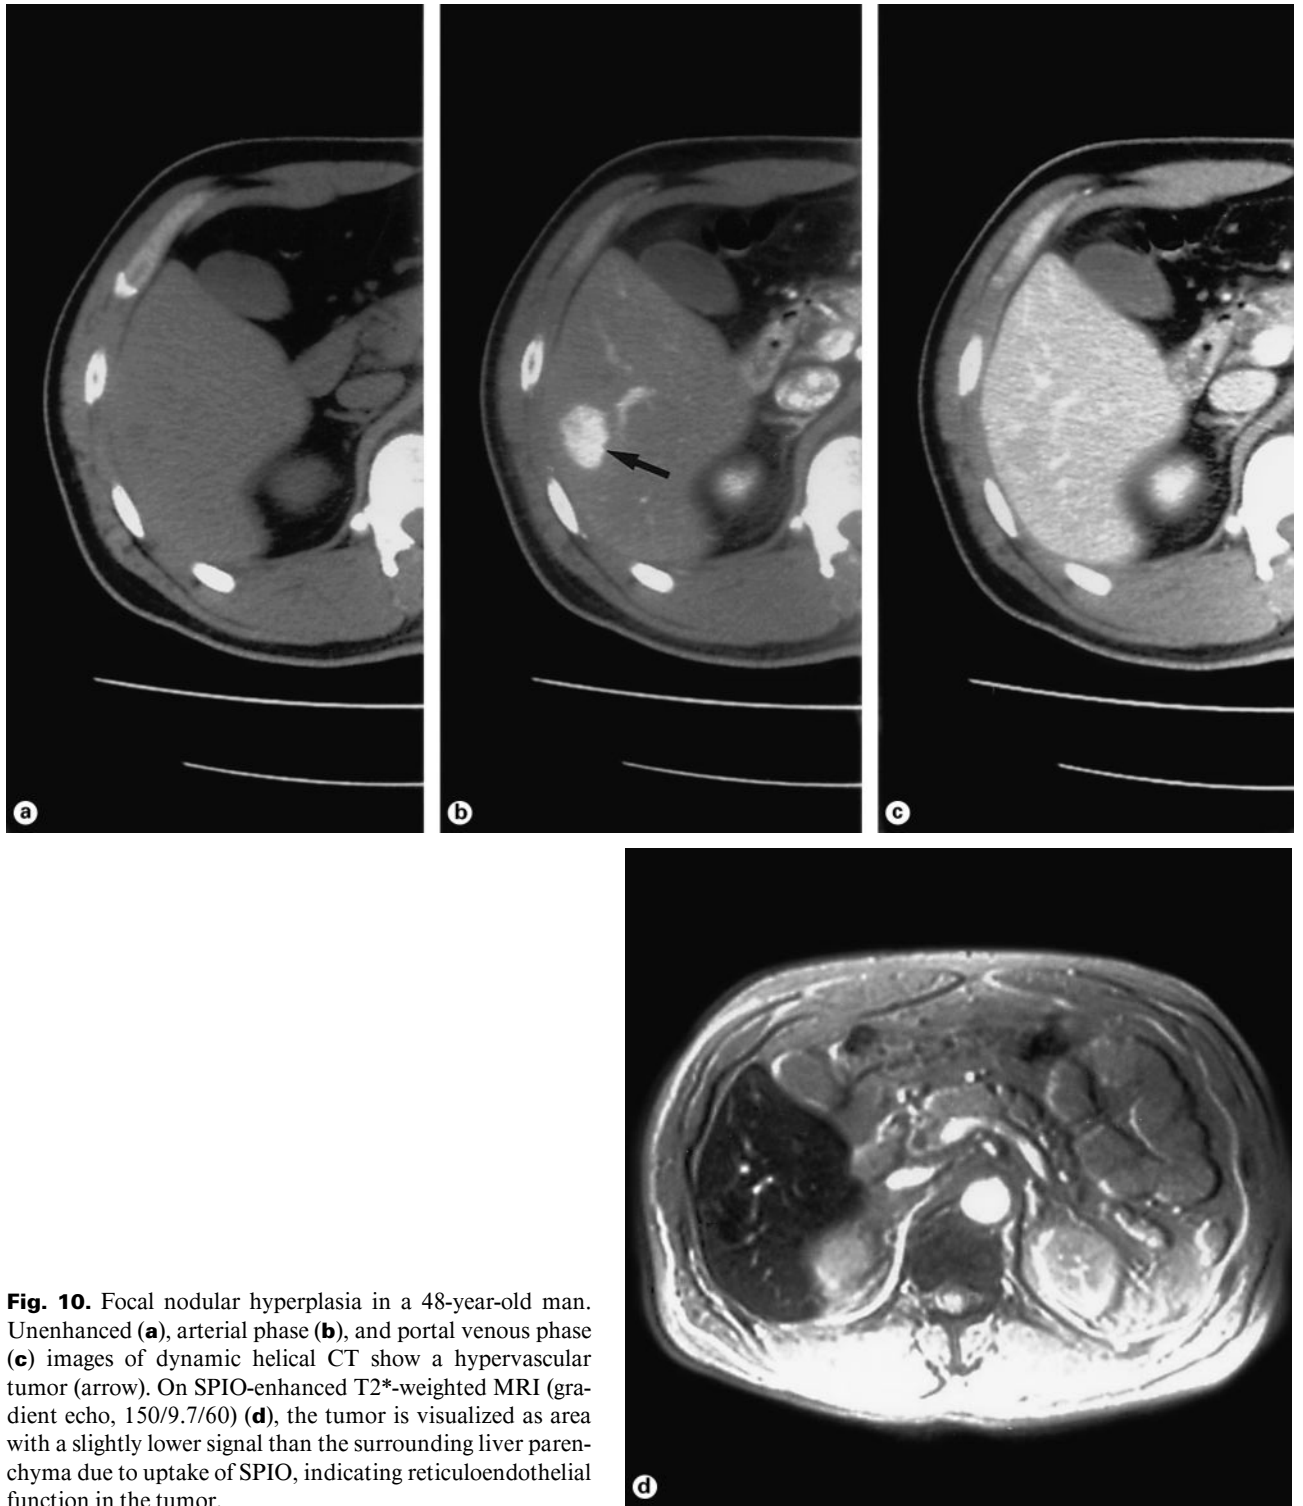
Focal nodular hyperplasia in a 48-year-old man. Unenhanced (a), arterial phase (b), and portal venous phase (c) images of dynamic helical CT show a hypervascular tumor (arrow). On SPIO-enhanced T2*-weighted MRI (gradient echo, 150/9.7/60) (d), the tumor is visualized as area with a slightly lower signal than the surrounding liver parenchyma due to uptake of SPIO, indicating reticuloendothelial function in the tumor.
